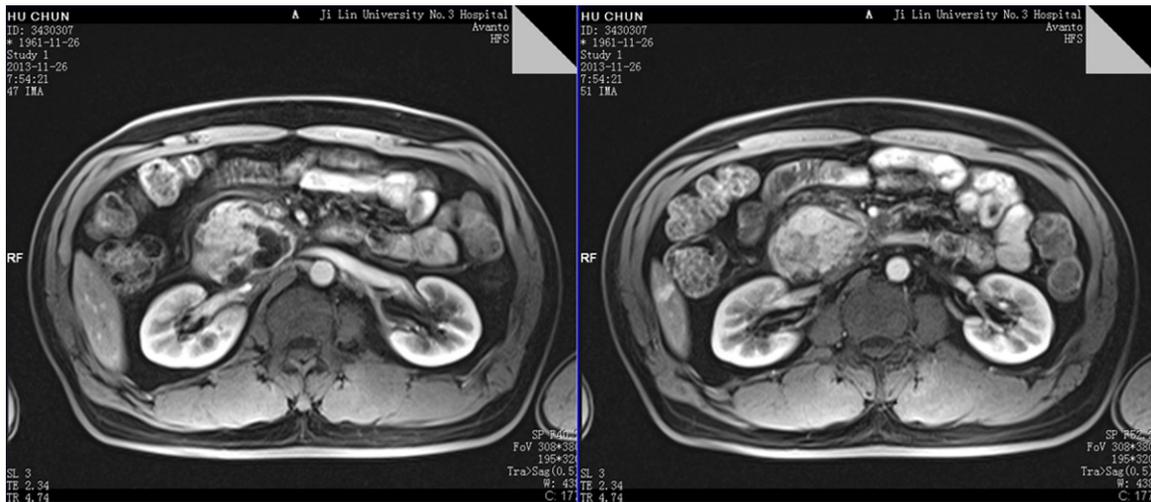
The MRI showed the string-of-beads dilation of branch pancreatic duct connected to the main pancreatic duct in the enlarged head of pancreas.
